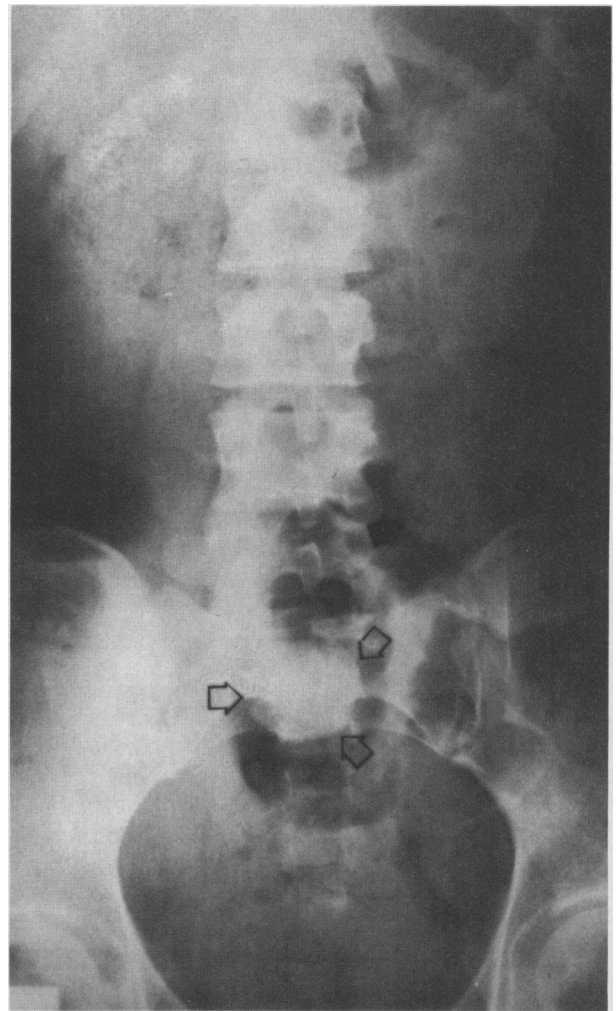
Radiographic examination of the second patient's abdomen revealed rounded opaque densities overlying the left sacral wing (solid arrows) and sacrum (open arrows)
